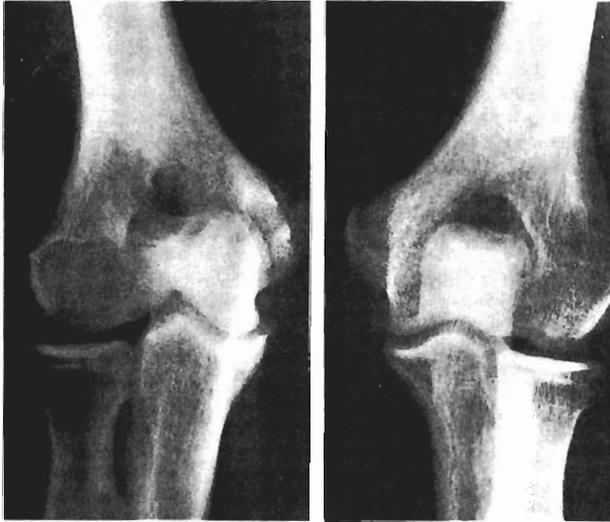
John, aged 19, sustained a fracture of the lateral condyle at the age of 7, and the fragment was sutured in place. He now has a full range of movement and no symptoms. The lateral condyle is prominent. The radiograph (*left*) shows deepening of the trochlear notch—almost a universal finding some years after this fracture. Compare the normal elbow (*right*).
